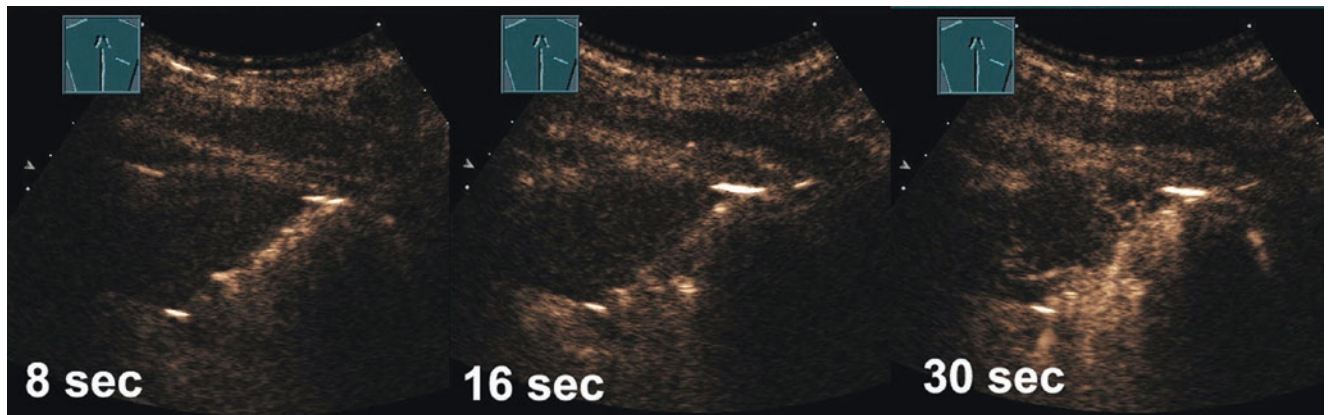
In contrast enhanced ultrasound pulmonary embolism shows a very late and less intensive enhancement – very well for differentiation of inflammatory consolidations
